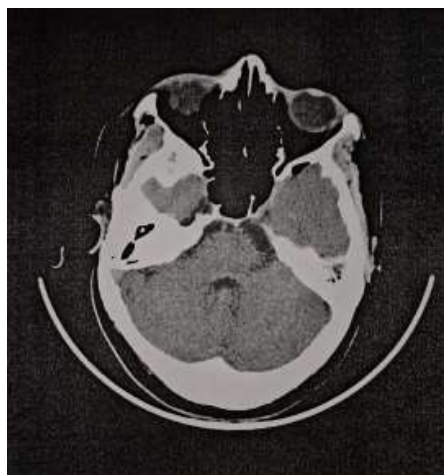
Postoperative axial CT of the brain showing no residual tumor or hemorrhage.
